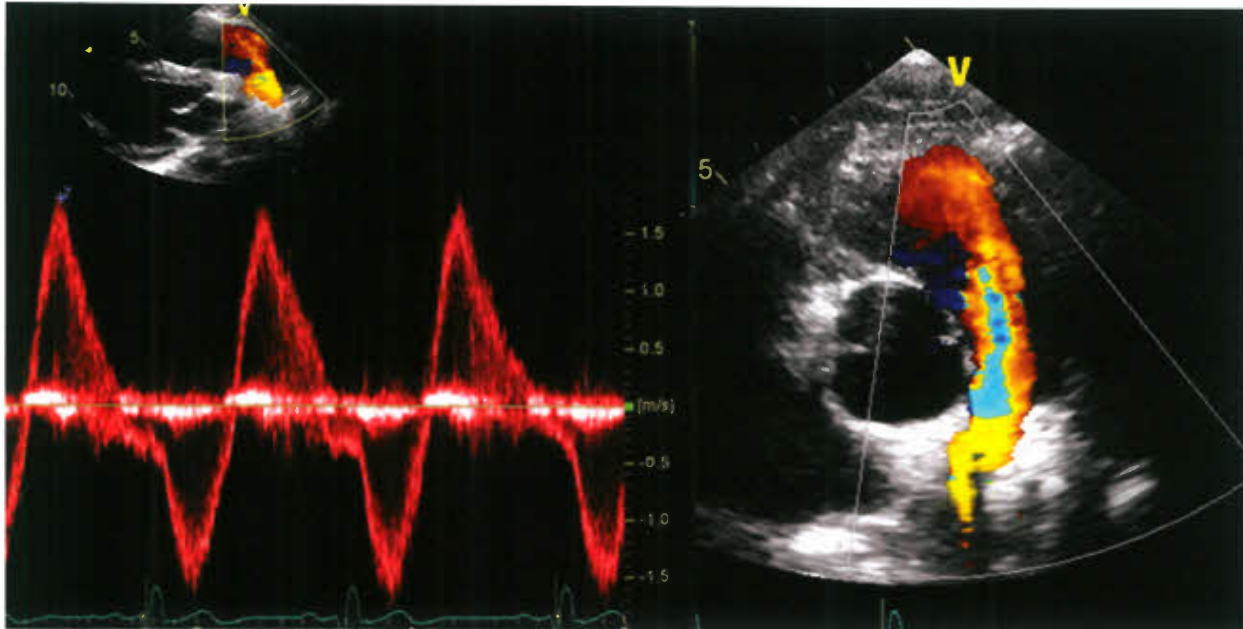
Severe pulmonary regurgitation after TOF repair. A wide regurgitant jet can be seen in the main pulmonary artery originating distally from the right pulmonary artery. The Doppler pattern shows the protodiastolic duration of the jet with its termination late in diastole.
